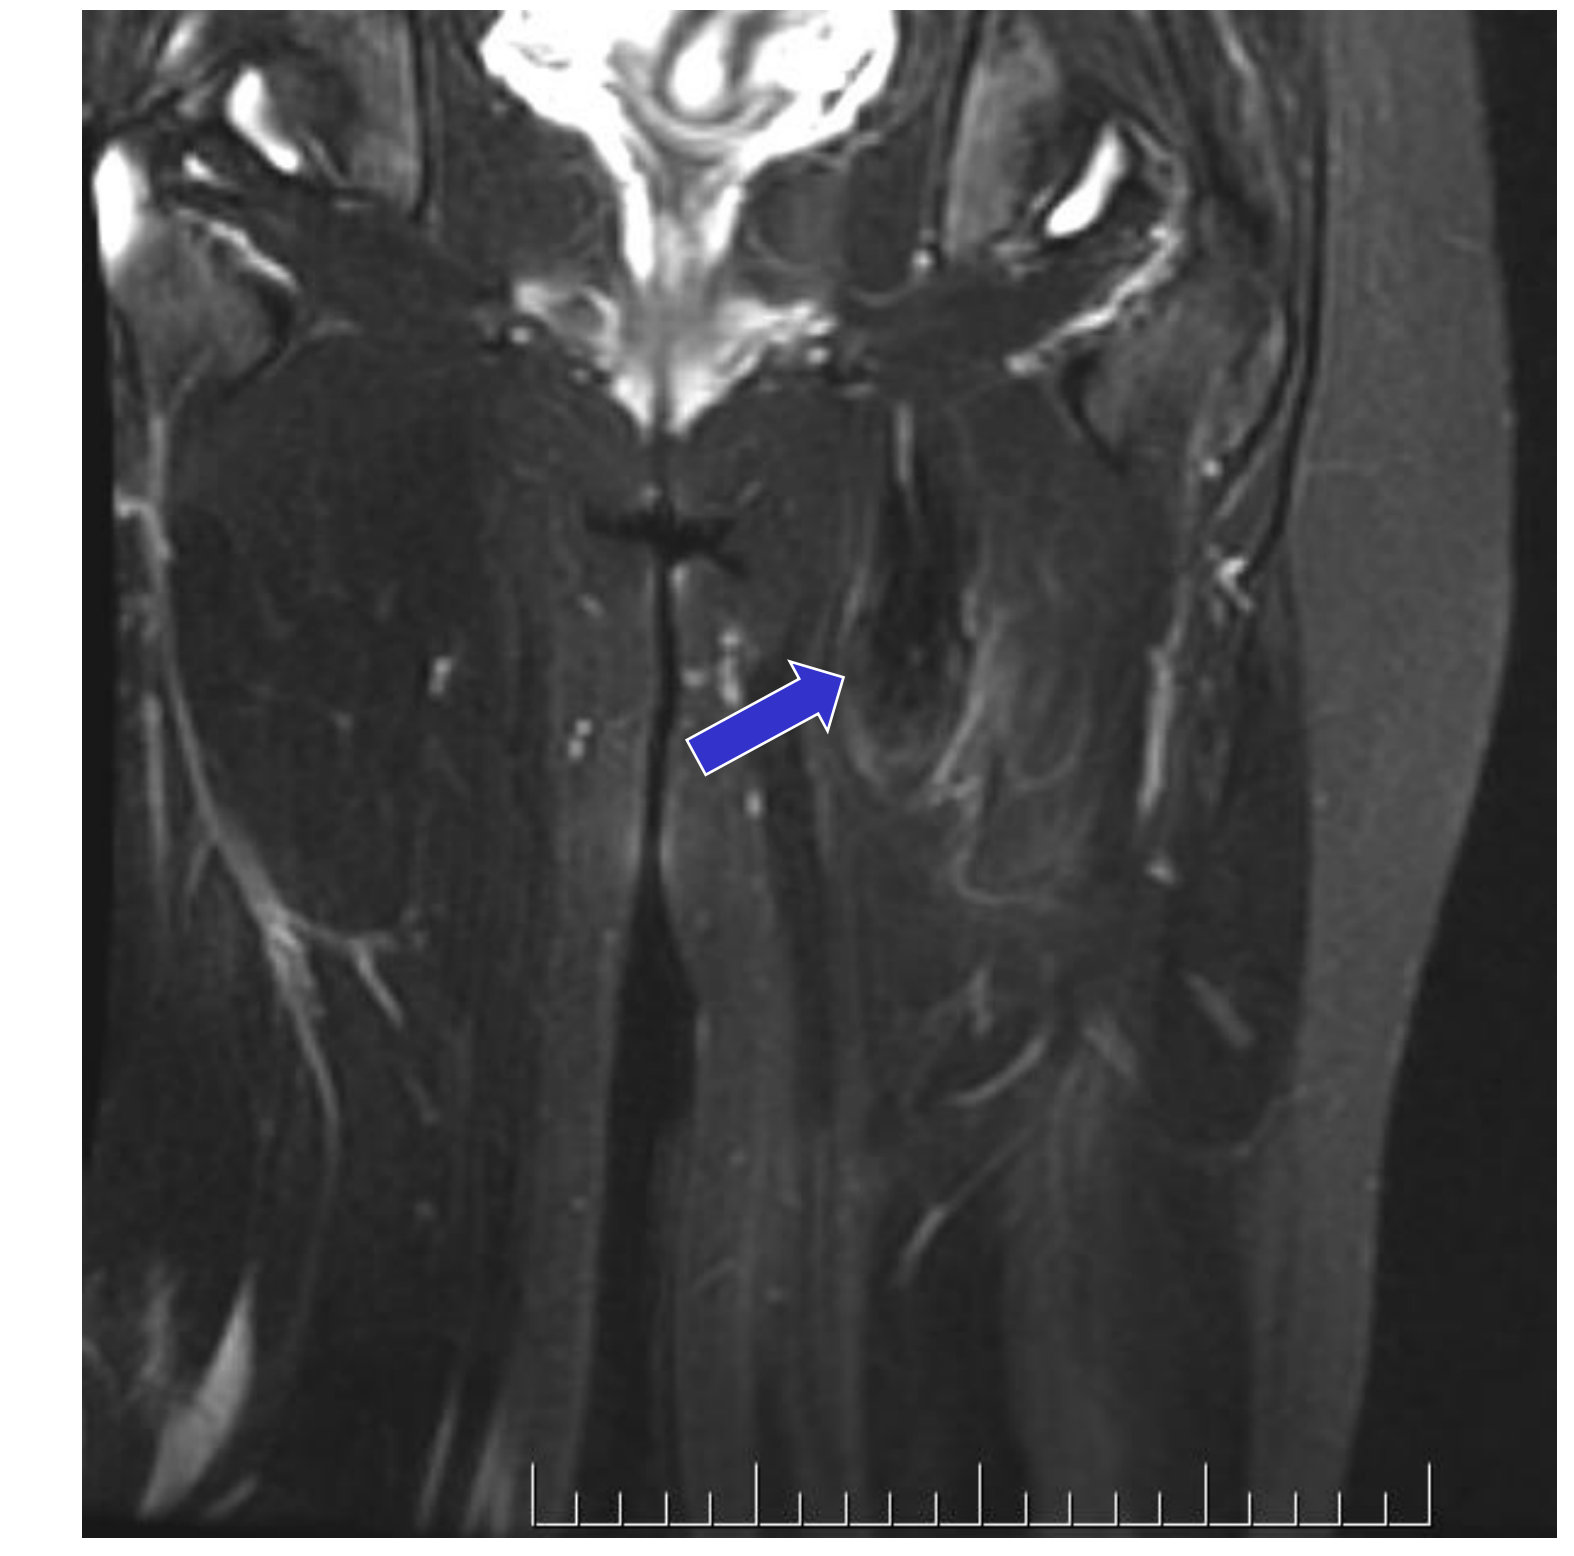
Post-treatment MRI (24 months)
